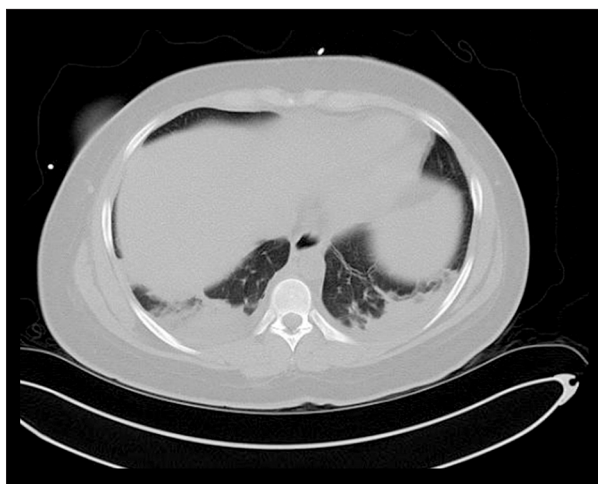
CT scan of the chest image without contrast showing bibasilar infiltrates.
